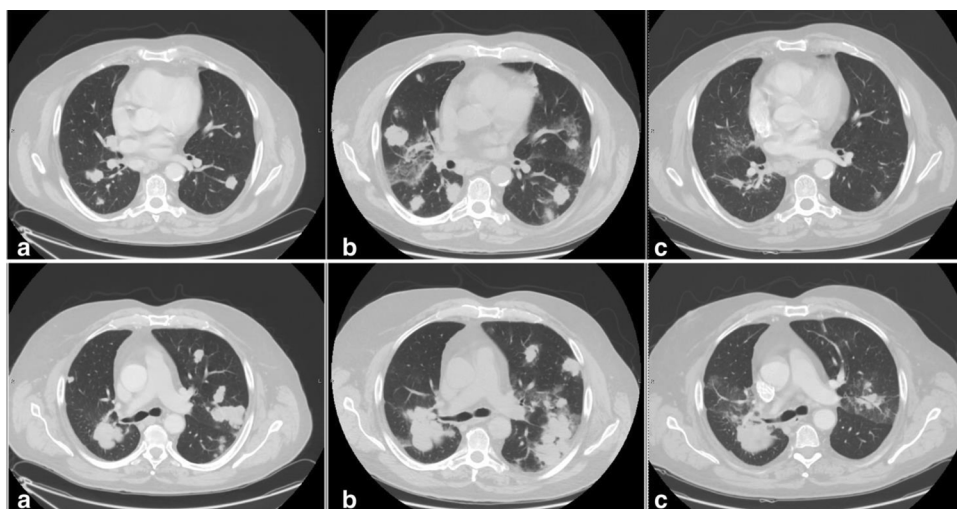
CT scans of PP from our casuistry. A Caucasian 65-years old man diagnosed with stage IV NSCLC treated with four different chemotherapy lines from September 2013 to September 2015, the last with 7 cycles of Vinorelbine with SD (a: December 2015 CT). In February 2016 he started treatment with Nivolumab in the expanded access program; after ten days he was hospitalized due to respiratory failure with nodal and pulmonary lesions increase with ground glass area (b). Microbiological investigations were negative and steroid therapy was started (methylprednisolone 1 mg/kg) with clinical and radiological improvement. Nivolumab therapy was resumed and CT evaluation after eight cycles (June 2016, c) showed a good PR.
